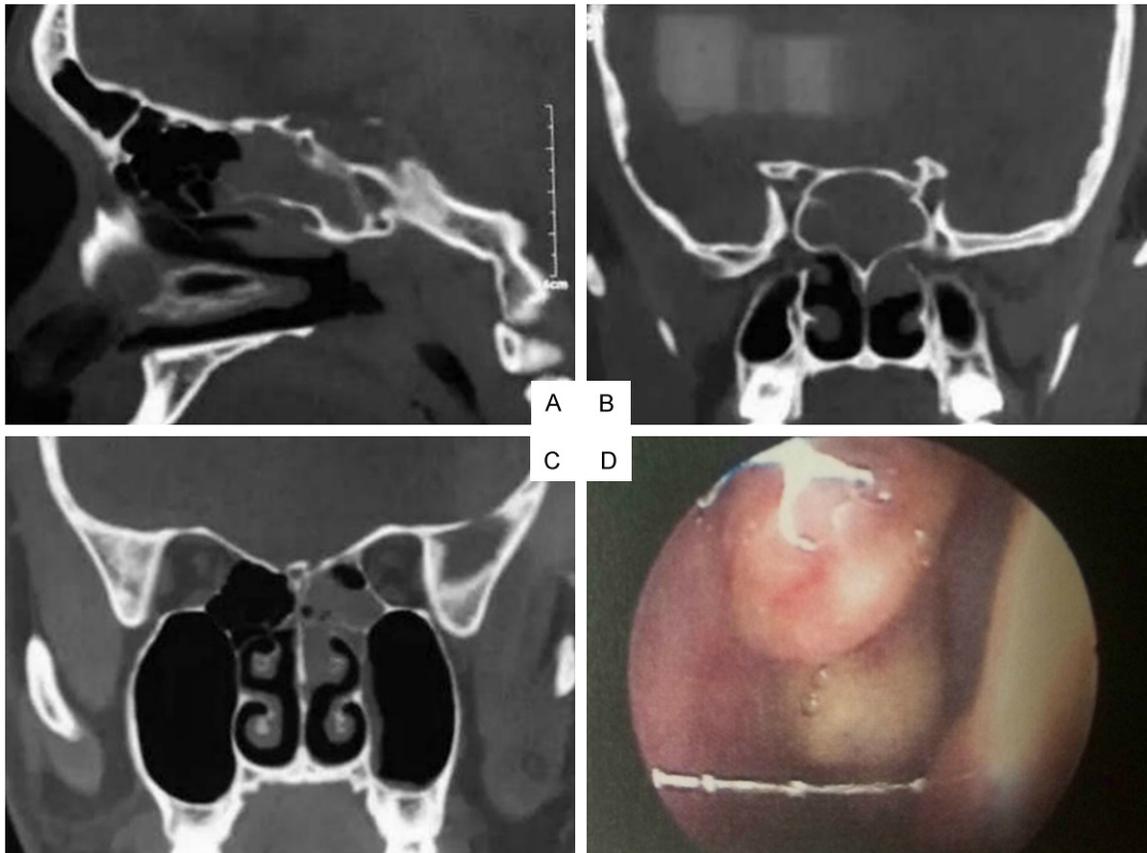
CT scans (A-C) showed soft tissue shadows in the sphenoid sinus, ethmoid sinus and nasal tract. Nasal endoscopy (D) demonstrated the neoplasm in the olfactory sulcus.
